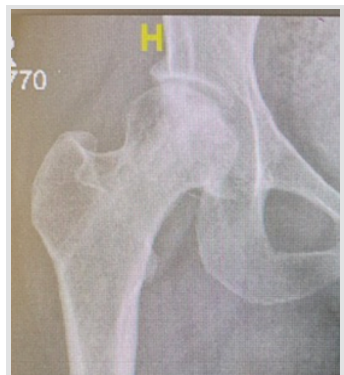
X-ray after 16 months of surgery.
